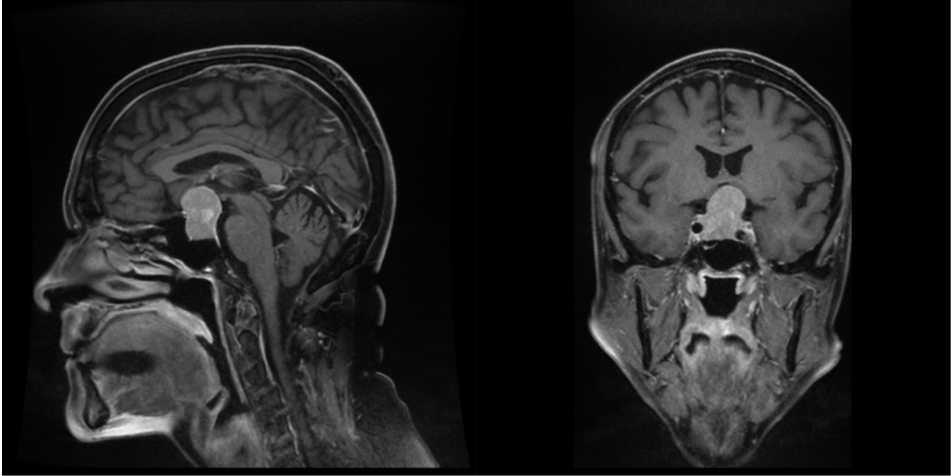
T1-weighted MRI with gadolinium contrast displaying a non-functioning pituitary adenoma from a sagittal (*left*) and coronal (*right*) view.
